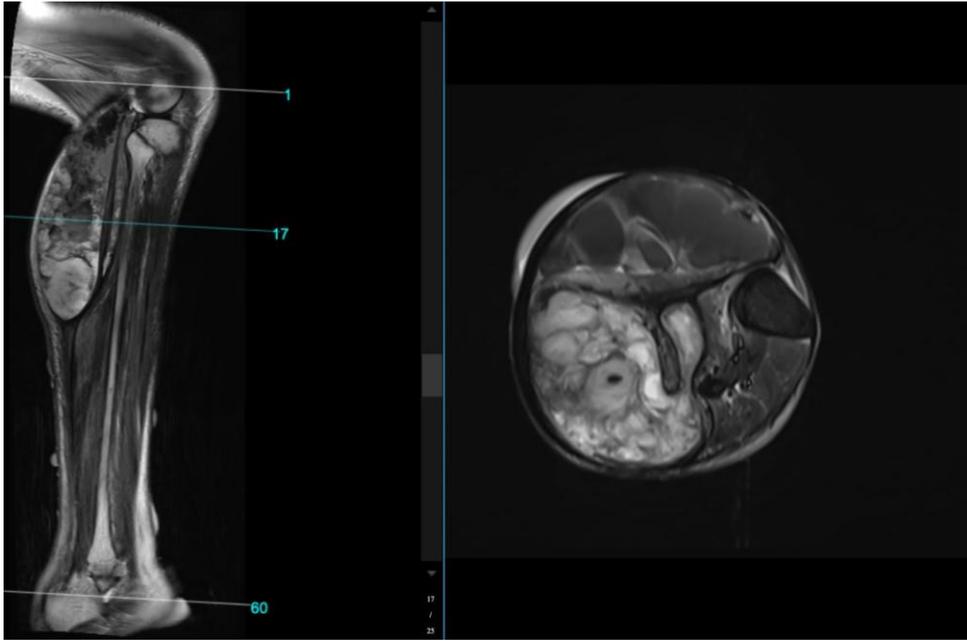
MRI left leg T2W axial view
